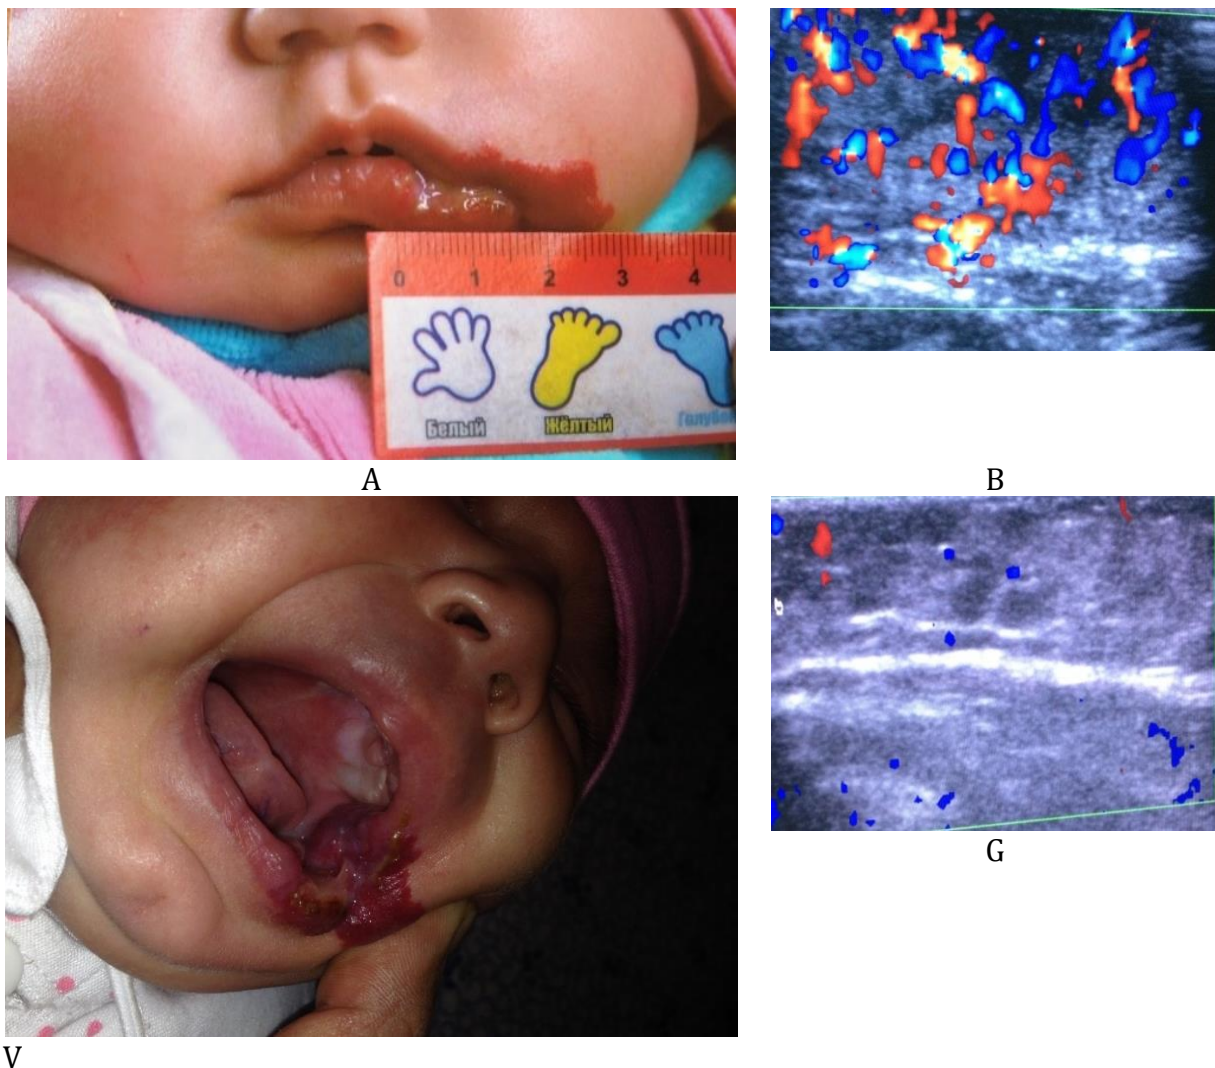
Patient K. 6 months. Diagnosis: right corner of the lower lip and mouth with cavernous hemangioma, wound complication (A) and dopplerography picture of the same condition (B). Hemangioma post laser destruction (V) and dopplerography (G) picture.
